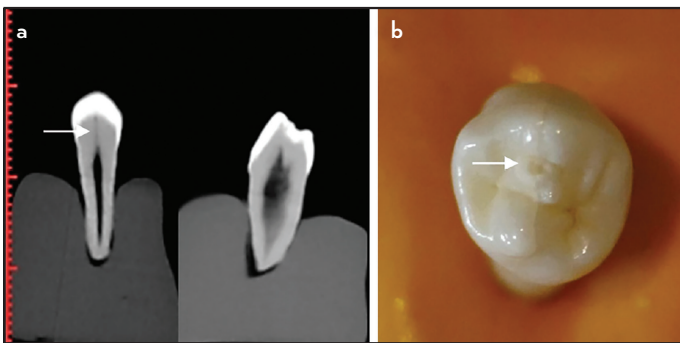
(a) CBCT images of an extracted first lower premolar with dens evaginatus where a thin coronal extension of pulp tissue can be noted (arrow). Coronal and sagittal views are presented. (b) Photograph of its occlusal surface where a fractured or worn down tubercle can be observed
